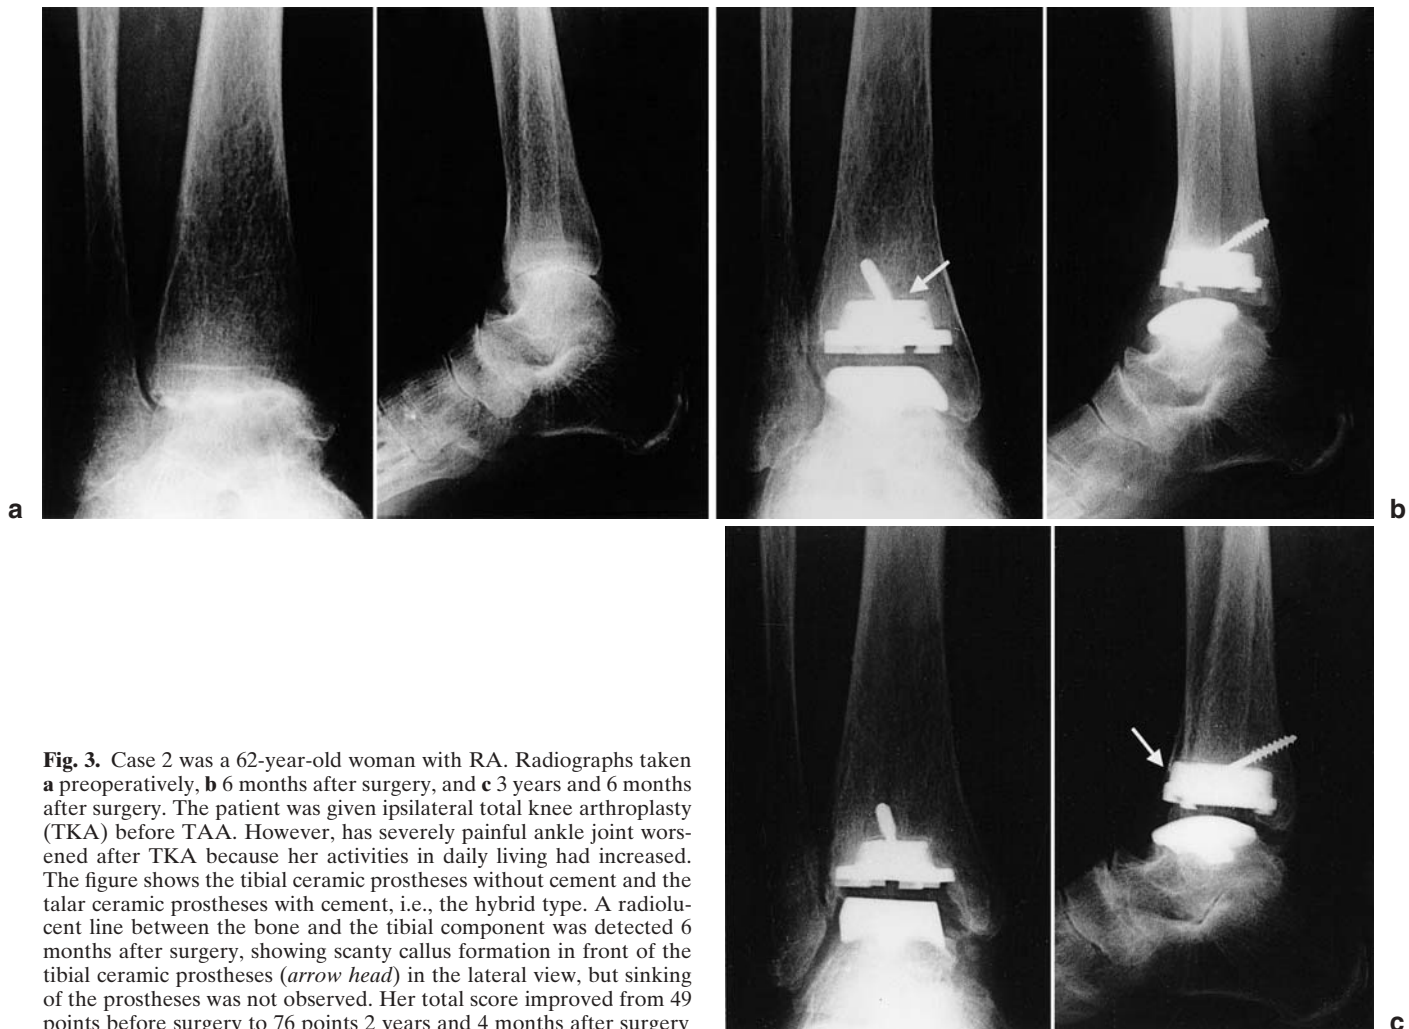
Case 2 was a 62-year-old woman with RA. Radiographs taken a preoperatively, b 6 months after surgery, and c 3 years and 6 months after surgery. The patient was given ipsilateral total knee arthroplasty (TKA) before TAA. However, has severely painful ankle joint worsened after TKA because her activities in daily living had increased. The figure shows the tibial ceramic prostheses without cement and the talar ceramic prostheses with cement, i.e., the hybrid type. A radiolucent line between the bone and the tibial component was detected 6 months after surgery, showing scanty callus formation in front of the tibial ceramic prostheses (*arrow head*) in the lateral view, but sinking of the prostheses was not observed. Her total score improved from 49 points before surgery to 76 points 2 years and 4 months after surgery
